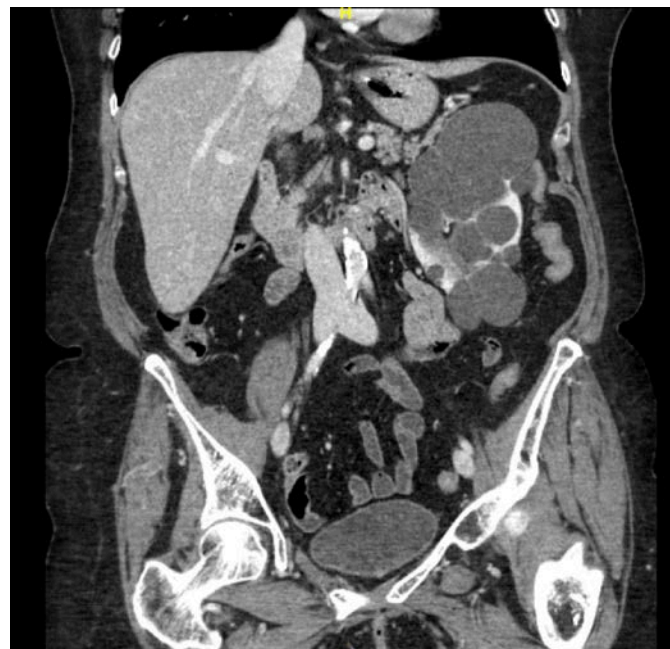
Coronal CT image demonstrating left kidney with multiple cysts involving the entire kidney and enlarged appearance.
